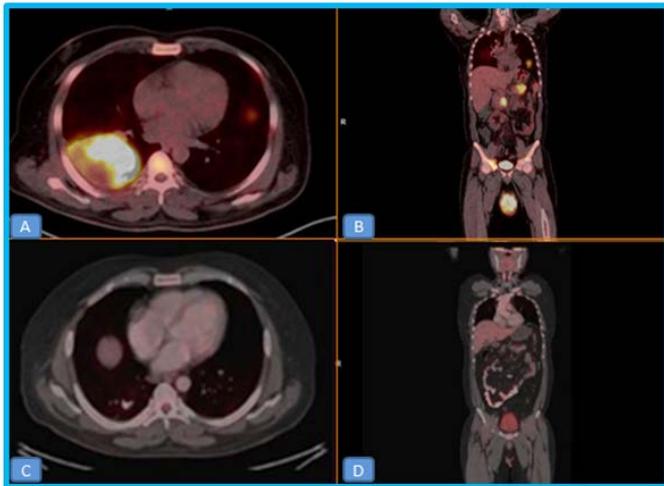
PET-CT at diagnosis (A & B) showing metabolically enhancing right testicular mass lesion, right adrenal, pancreatic, bone lesions with enlarged Para-aortic lymph nodes and following 3 cycles of chemotherapy (C & D) showing metabolic resolution all the lesions.
